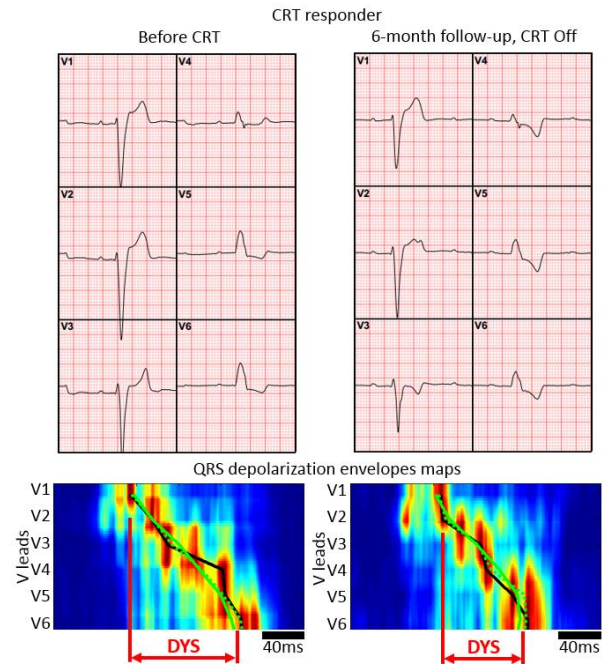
Example of the CRT responder by echocardiography (ESV increase by 27%); with almost no change of QRSd (193ms to 191ms), but the substantial decrease of DYS (109ms to 79ms). QRS depolarization envelopes maps are created by amplitude normalization over the V lead envelopes (max. amplitude – red, min. amplitude – blue color), arranging envelopes into rows from V1 to V6 and performing a linear interpolation between the rows.
